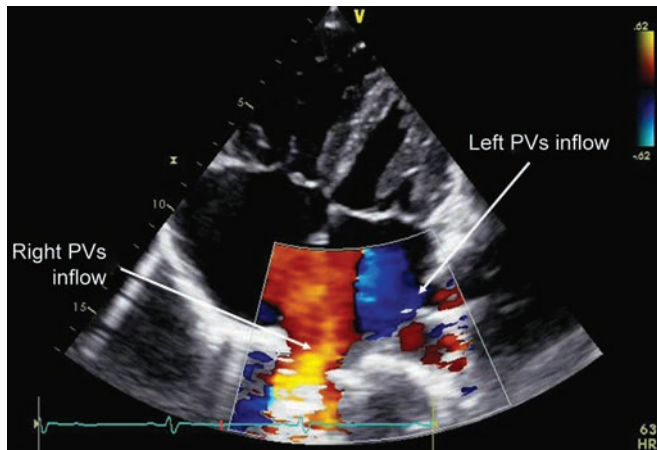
Apical four-chamber color Doppler view showing right- and left-sided pulmonary venous inflows
